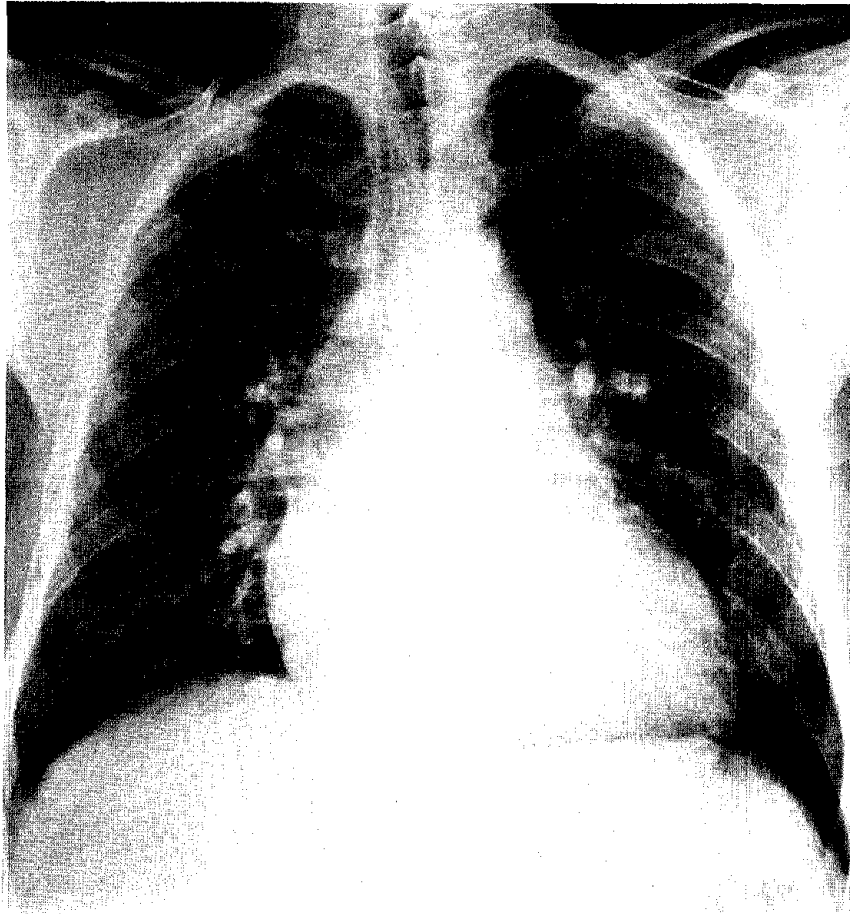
"Cone cut". The x-ray beam is limited to only a small amount of tissue below the costophrenic angles. It is adjacent to the outer margins of the edges of the ribs and includes only a small amount of the tissue in the neck area just above the lung apices. It is mandatory that the edges of the beam ("cone cut") be visualized on the film.
